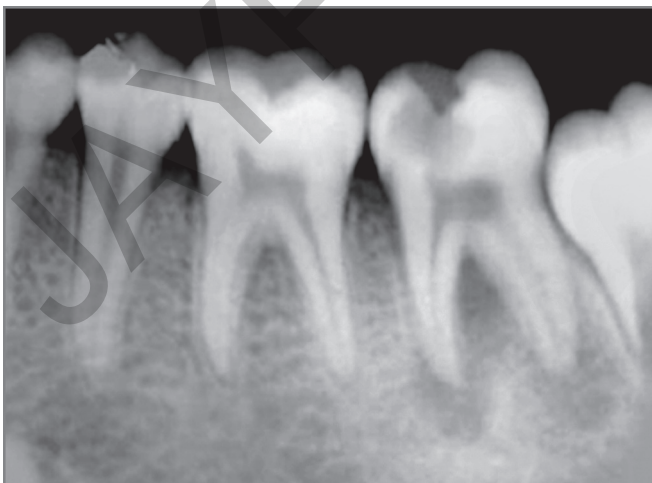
Periapical rarefaction seen in chronic periapical infection.
